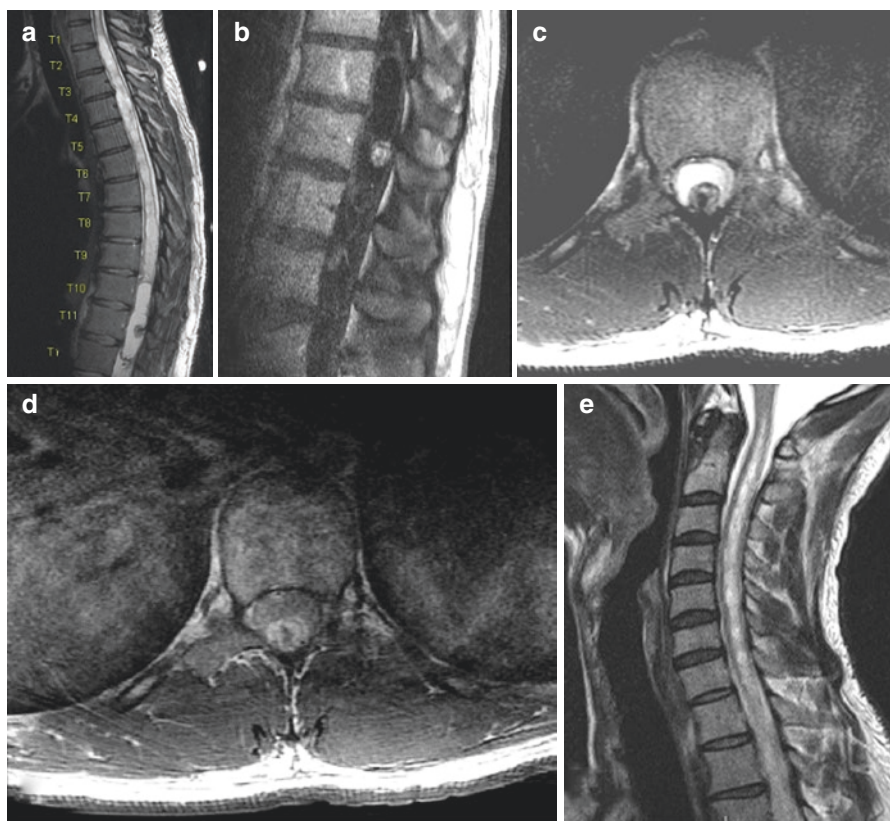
Thoracic spinal cord hemangioblastoma (Patient 2: non-VHL disease, male patient operated by the senior author, KIA) [58]. (a) Preoperative MRI of spine. (b) T2-weighted sagittal MRI showing holocord spinal syrinx (above the lesion) and hypointense spinal cord hemangioblastoma at T11 surrounded by cyst. (c) T1 post-contrast sagittal MRI showing enhancing tumor nodule. (d) T2-weighted axial scan showing a tumor nodule. (e) T1 post-contrast axial MRI showing an enhancing tumor nodule. (f) Sagittal T2-weighted MRI showing syrinx extension to the brain stem
